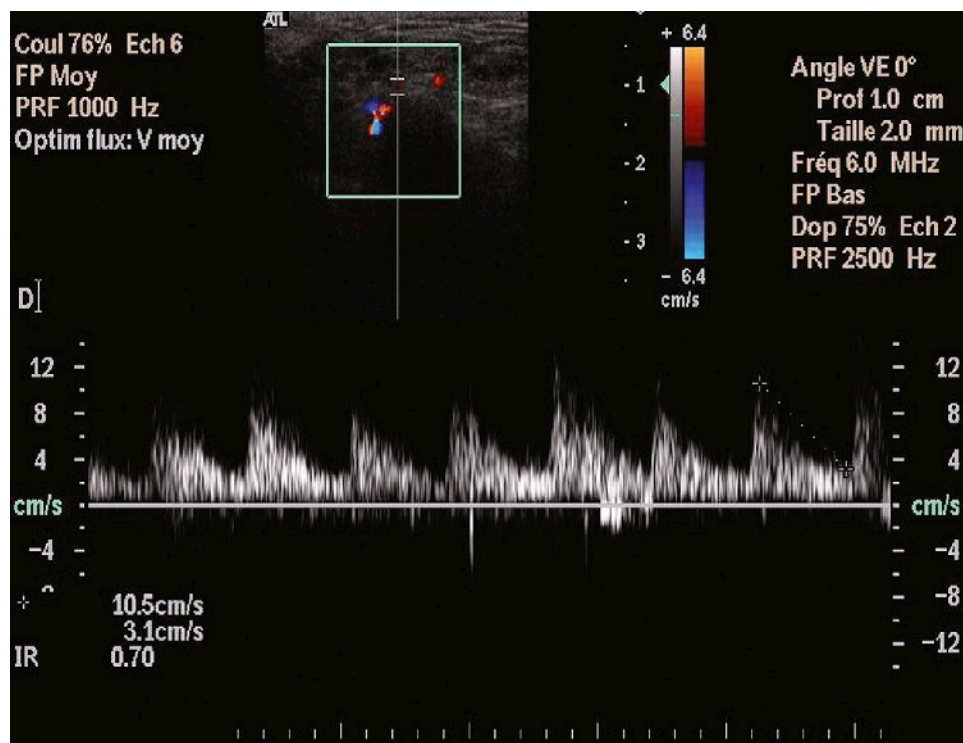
A Doppler waveform is seen on a transverse view of the facial artery in a control during lemon stimulation. The systolic peak decreased, and there was decreased impedance in the parotid vessels and a decrease in the resistive index ($RI = 0.70$).
